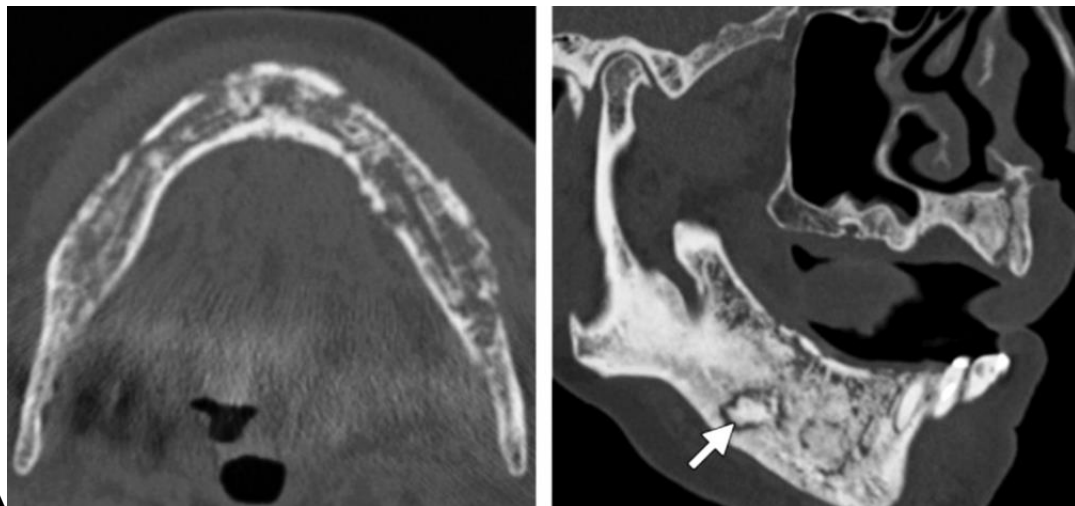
BRONJ in two patients. Axial (A) and sagittal reformatted (B) CT images show symmetric, poorly marginated, mixed sclerotic and lytic lesions throughout the mandible with multiple cortical interruptions. The lesions are bilateral. An area of evolving sclerotic necrotic bone (arrow in b) is also seen.
